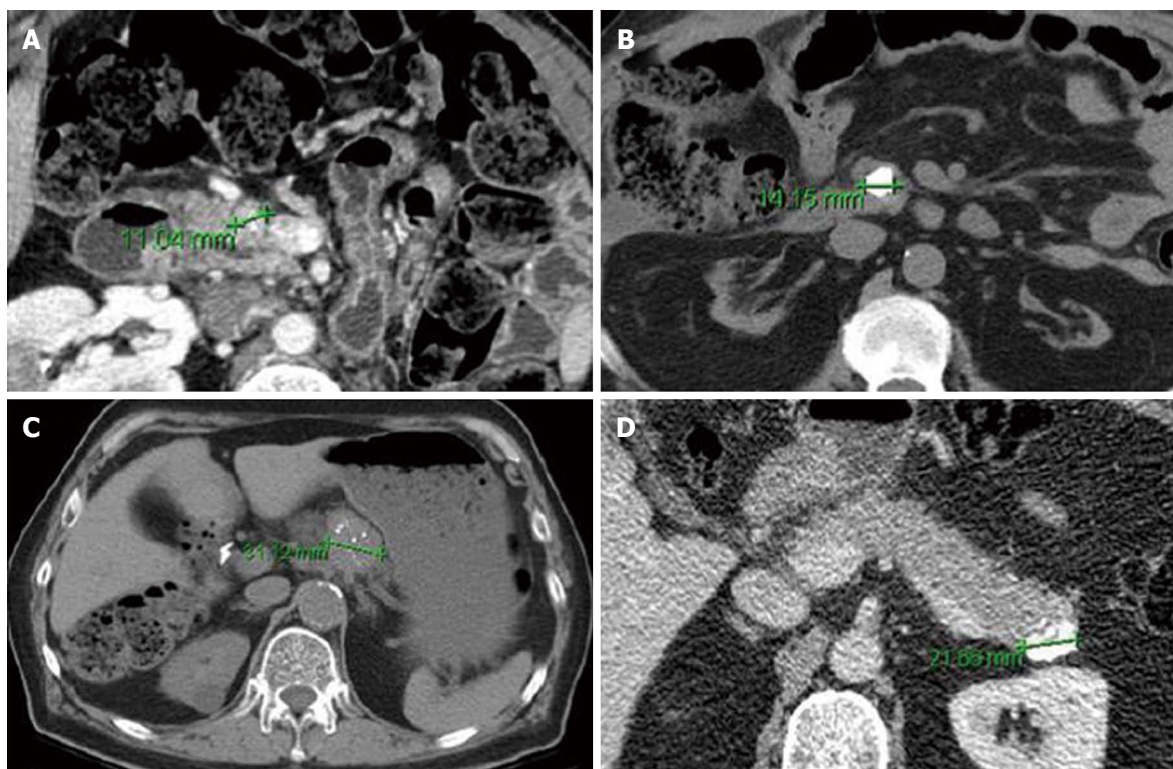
Axial computed tomography images of Pancreatic neuroendocrine tumor with punctate (A, C) and dense/coarse calcifications (B, D). Despite their small size, all lesions were associated with either lymph node metastasis (A-C) or intermediate (G2) grade (B-D) on pathologic evaluation (From Poultides *et al*^[36]. Pancreatic Neuroendocrine Tumors: Radiographic Calcifications Correlate with Grade and Metastasis. *Ann Surg Onc* 2012; 19: 2295-2303).
